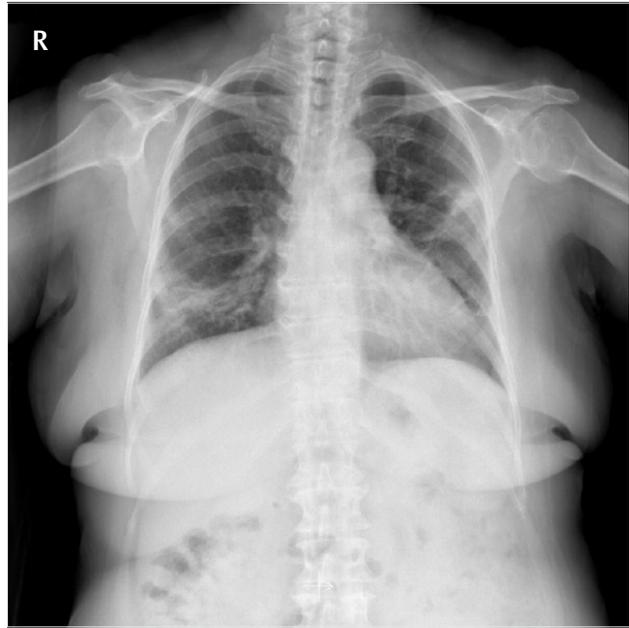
After treatment, decline in lesions on posteroanterior chest radiograph taken for control
